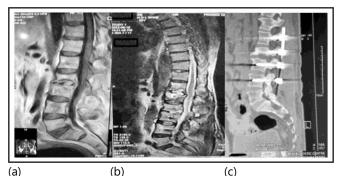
(a): MRI lumbosacral spine showing L2 disc disease, possibly caries spine.
